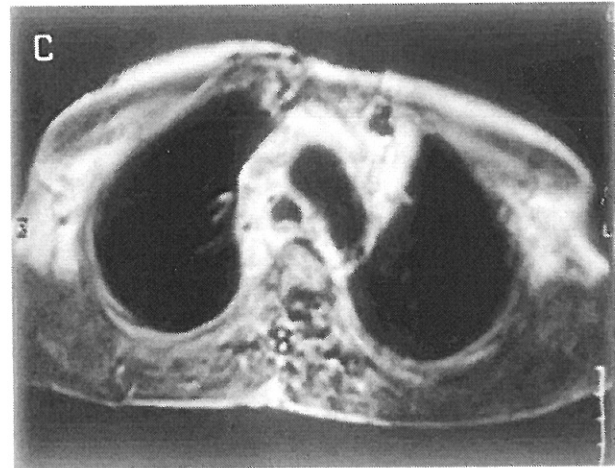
Mediastinal mass lesion shows heterogeneous contrast enhancement after intravenous gadolinium administration on T1-weighted image.
